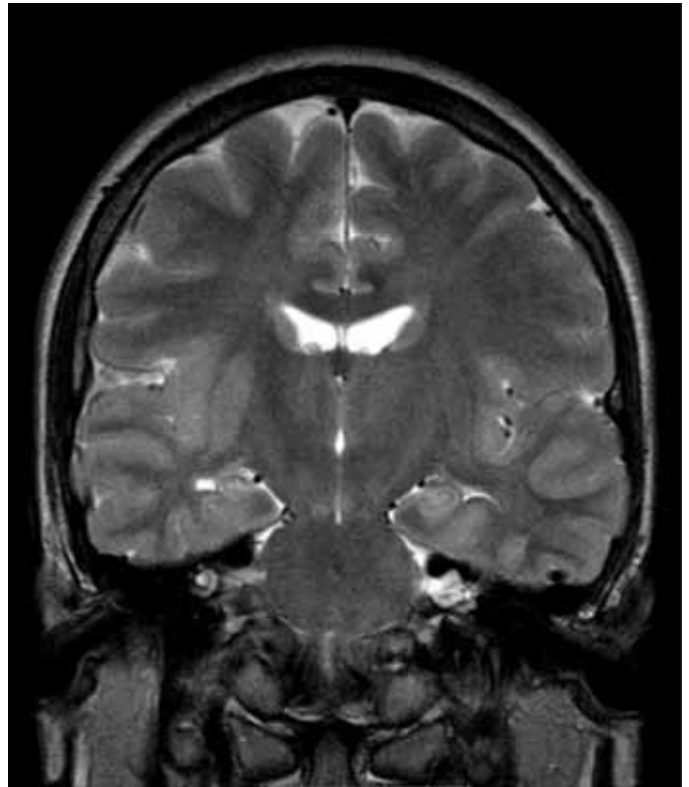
T2-weighted brain MRI: Coronal view showing right mesial temporal sclerosis.
